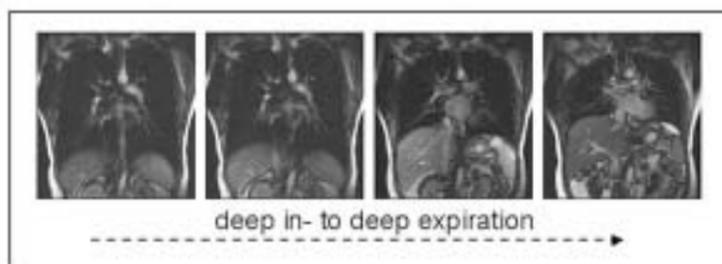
Dynamic MRI of deep expiration in a healthy subject
